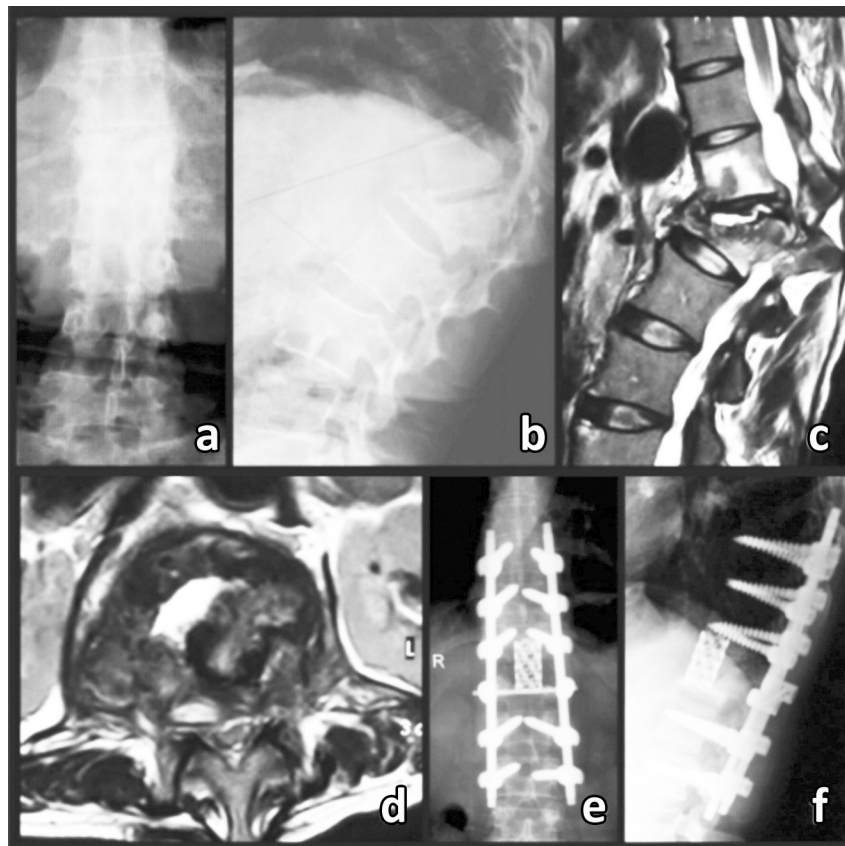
a, b, c, d - Pre-operative plain x-rays and MRI of 46 /F showing significant vertebral collapse and kyphosis at L 1 level. e, f - One year post-operative imaging showing excellent correction and spinal alignment.
